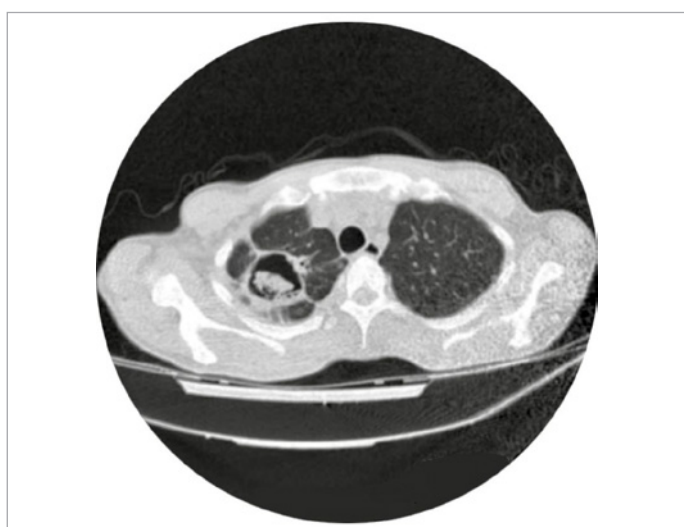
Computed tomography image of cavitary aspergillosis observed in the right upper lobe of the lung.
